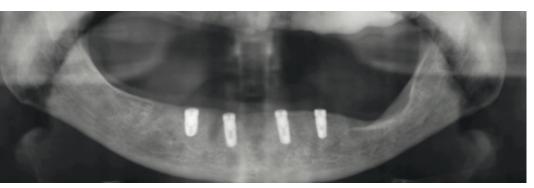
The x-ray control shows four CAMLOG® SCREW-LINE implants which were placed with virtually parallel axes.
